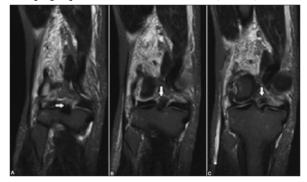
(A–C): MRI coronal STIR images in the posterior aspect of the knee joint shows, torn redundant PCL (arrow) lying over the posterior horn of medial meniscus
